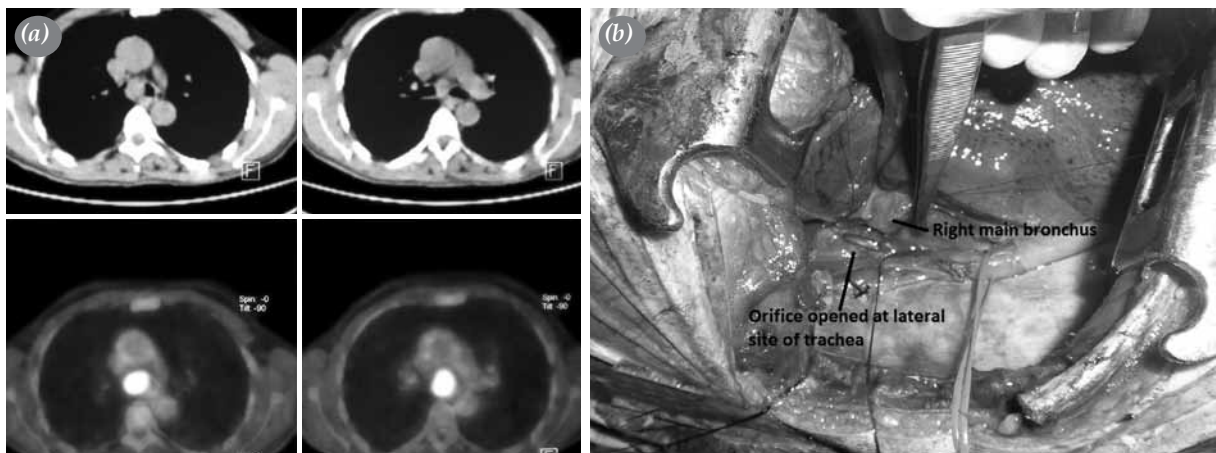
(a) Computed tomographic view of the tumor located at the tracheal carina. (b) Orifice opened at the lateral site of the trachea for the anastomosis with the right main bronchus.
